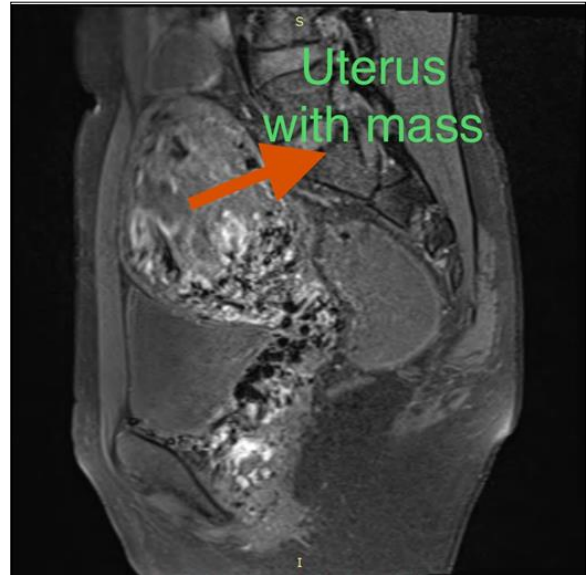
MRI image showing the mass and the uterus with extension to the bladder and vagina.
